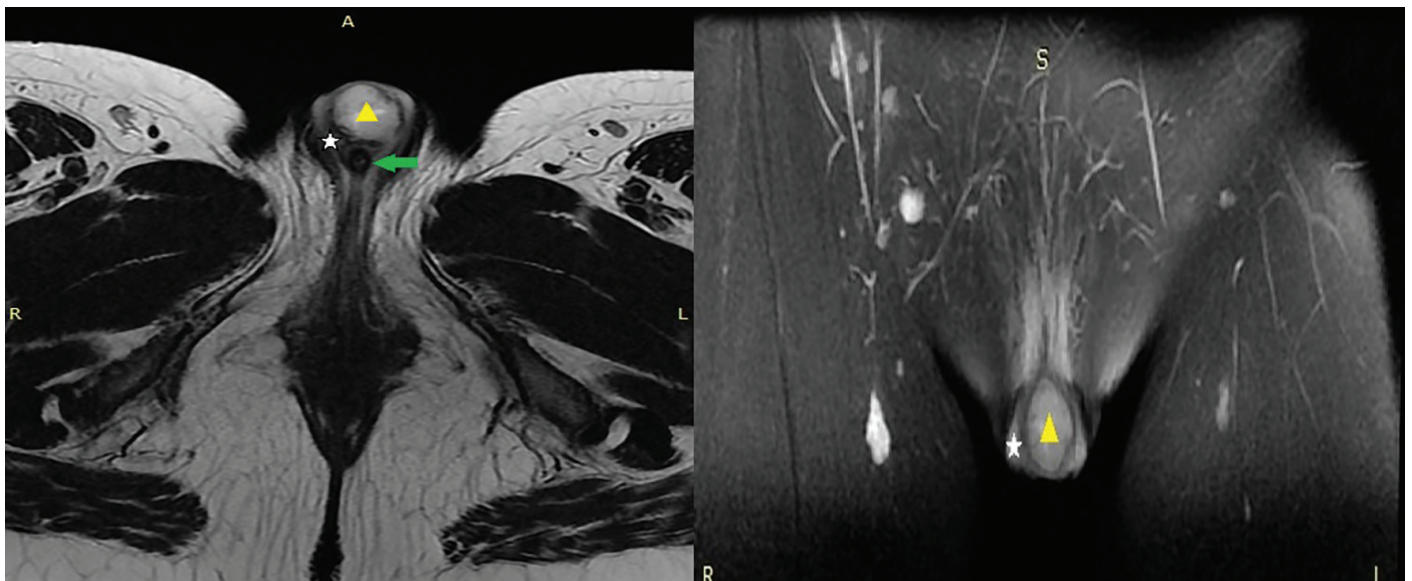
Pelvic MRI demonstrating a clitoral abscess asterisk: Clitoral body; triangle: Abscess cavity; arrow: Urethra
